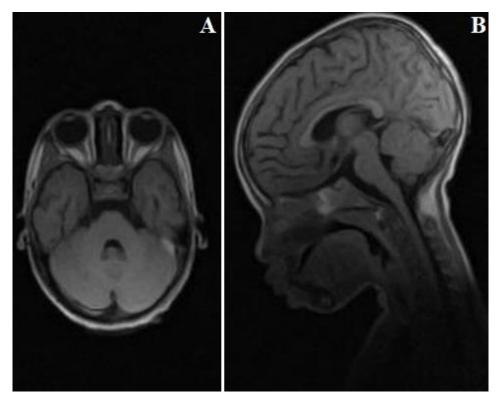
A) axial; B) sagittal magnetic resonance imaging at 4 weeks post trauma, demonstrating resolution of the retroclival subdural hematoma
